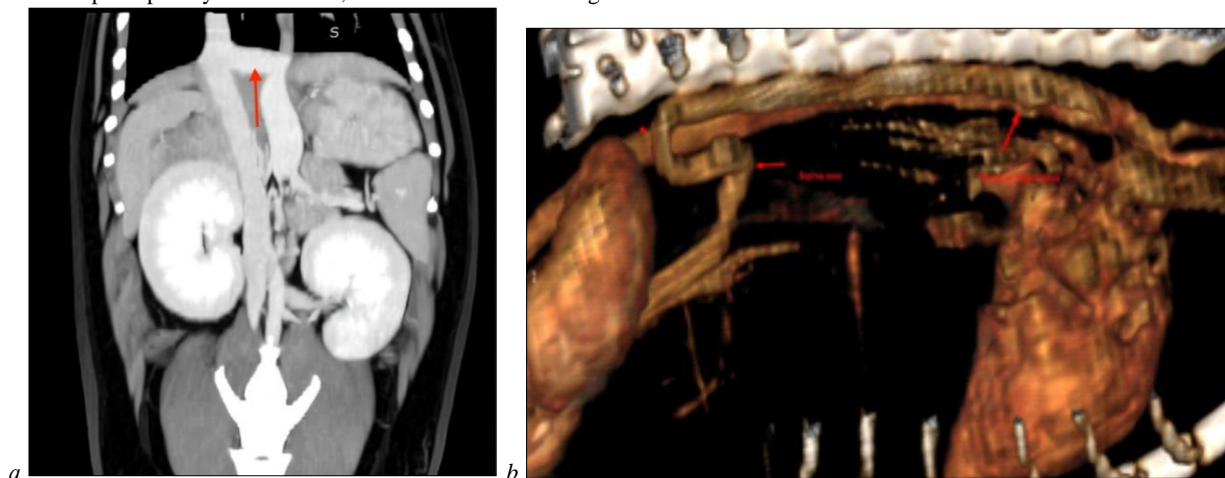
Computed tomography of extrahepatic portosystemic shunt; red arrows indicate the shunting vessels: *a* – vena gastrica bypasses the liver; *b* – aberrant shunting vessel
